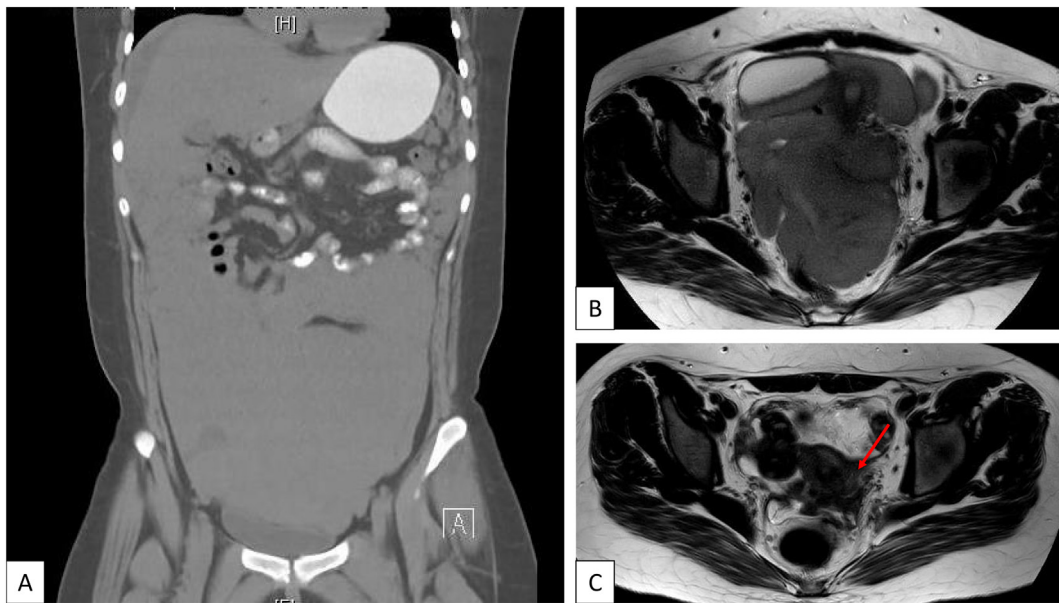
Magnetic resonance imaging (MRI). A coronal view at diagnosis shows extension to liver B axial view at diagnosis demonstrates the mass filling the pelvic cavity with unclear origin. C: After 2 cycles of neoadjuvant chemotherapy axial view shows normal-appearing uterus and ovaries and a 1.3 cm residual mass in the left adnexa (arrow).
